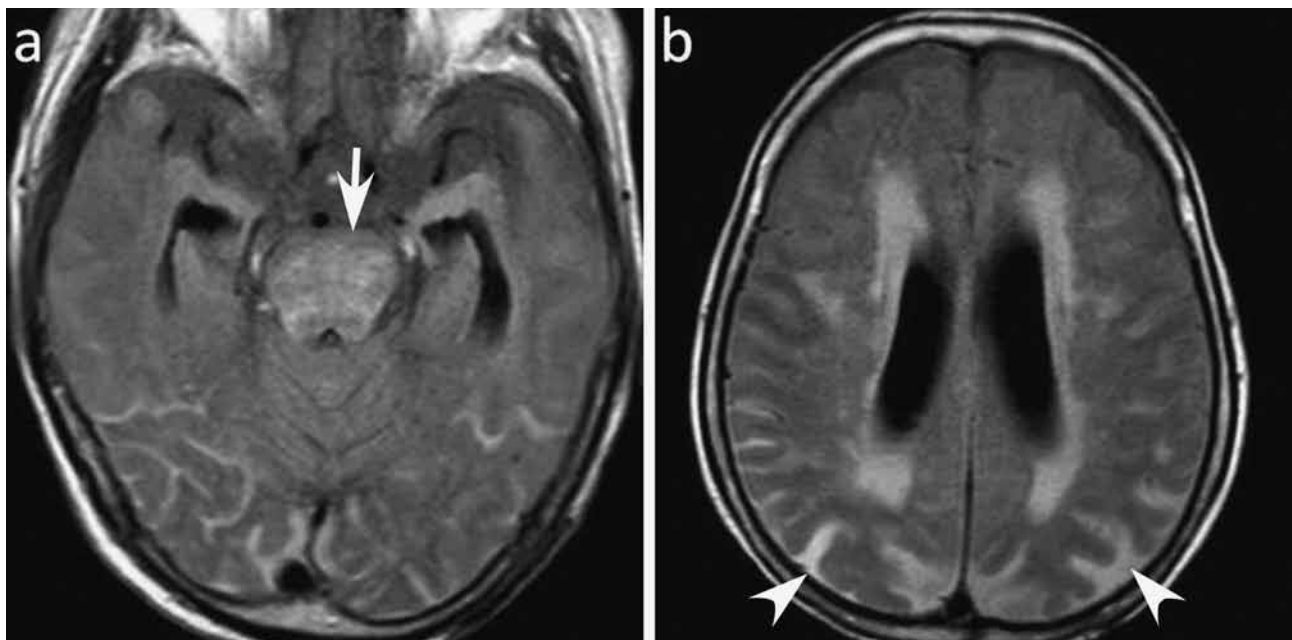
FLAIR image showing evident high signal intensity in the subarachnoid space, especially in the parietooccipital region (arrowheads) (repetition time/echo time = 10,000/120 ms, inversion recovery delay 2700 ms, multi-shot turbo spin-echo). Hyperintense signals can be seen in the pons (arrow) and periventricular areas due to hypertensive encephalopathy.
